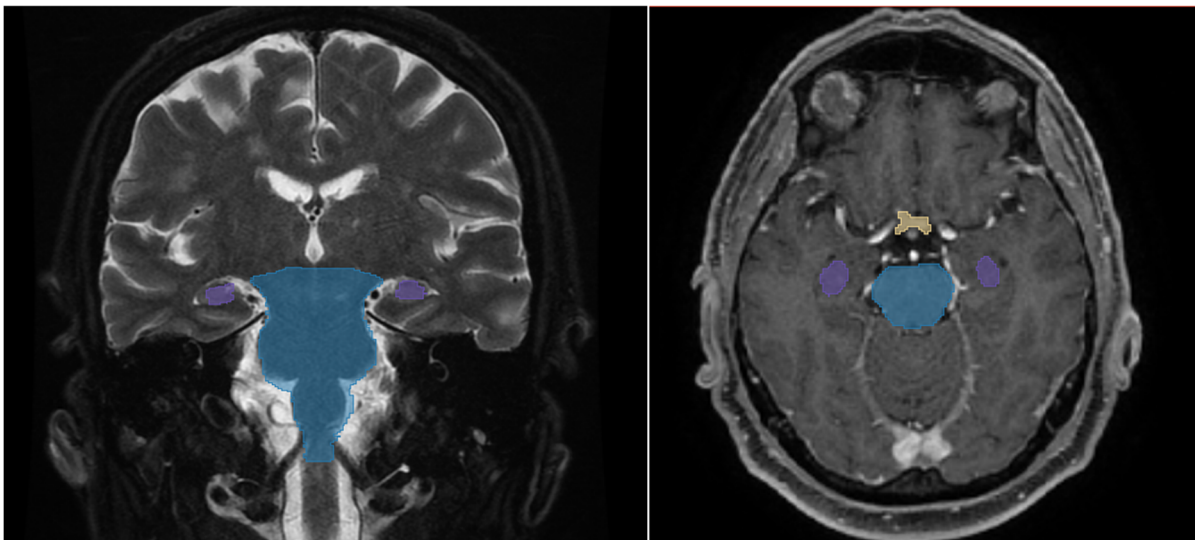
Examples of contouring of anatomical structures (hippocampi, brainstem, optic chiasm) on original noisy and denoised MRI images
